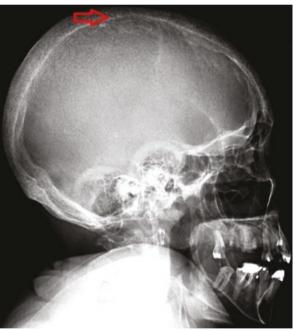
Plain X-ray of the skull (lateral view) showing mottling with salt and pepper appearance (red arrow) in osteitis fibrosa cystica
